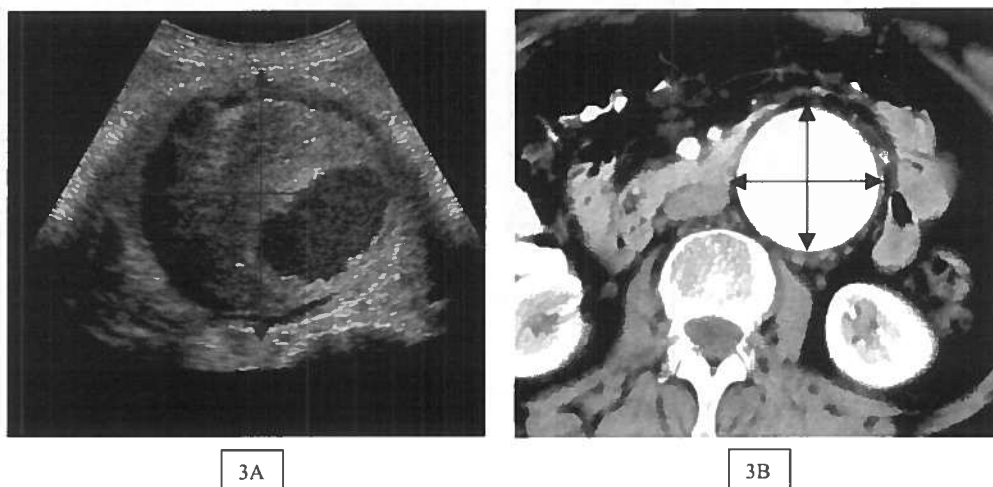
An axial scan of AAA with ultrasound (A) and CT (B). The arrows indicate the measurement sites of anterior-posterior and transverse plane measurements as used in the present study.
